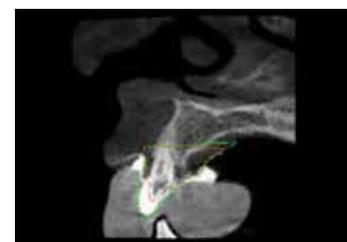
STL file repositioned over CBCT model along tooth outlines.
